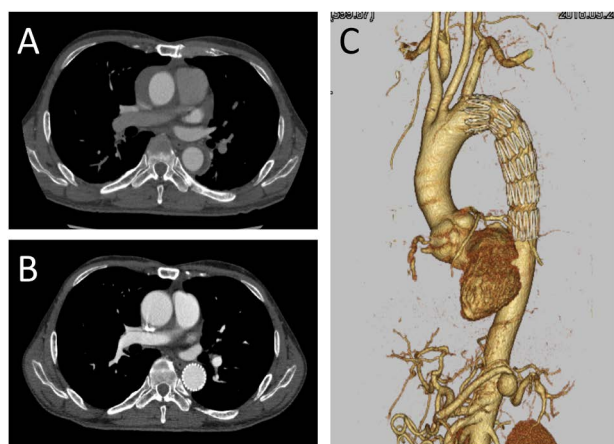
CT images of 44 year-old male with retrograde acute type A aortic dissection.
